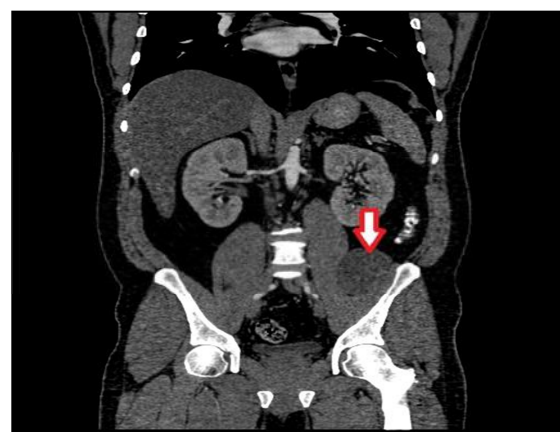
Coronal CT image of the abdomen-pelvis demonstrating hydatid cyst of the left psoas muscle.
